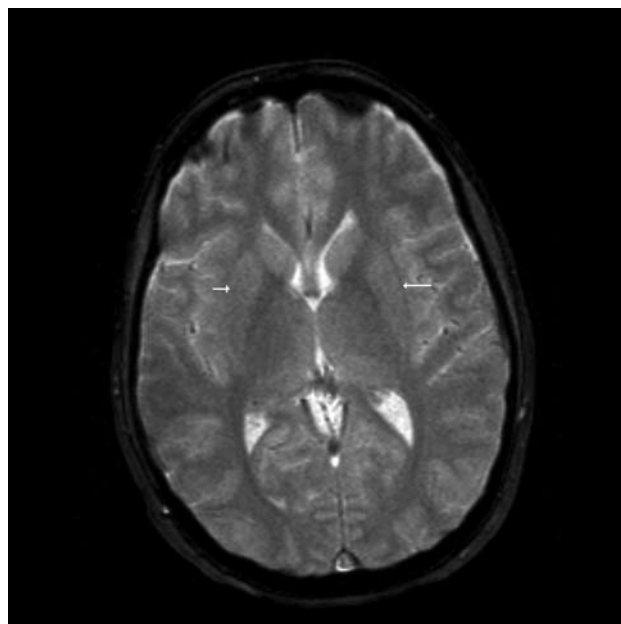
T2-weighted MRI of the brain from the same patient five days after the head CT scan. There are no parenchymal abnormalities noted and no evidence of infarction or bleeding. The basal ganglia are normal (white arrows). The patient at this stage has clinically improved.
